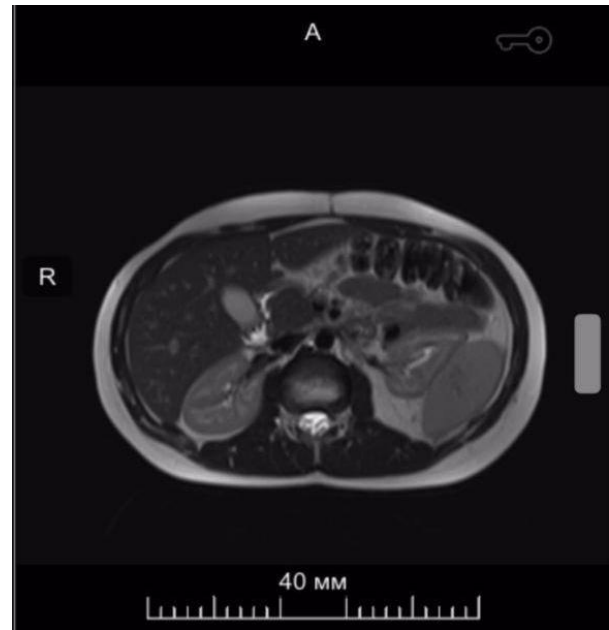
Axial view of MRI of abdomen.
